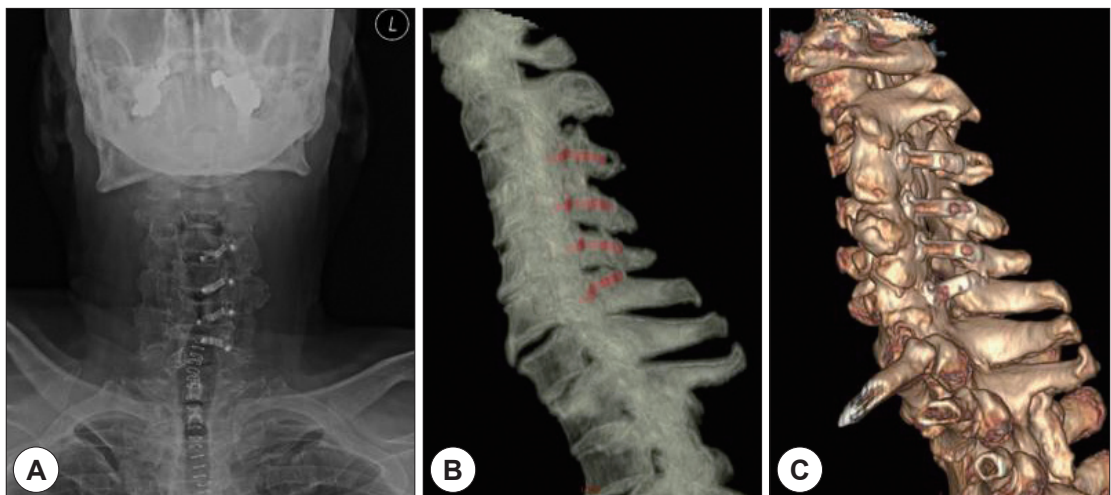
Radiologic images demonstrating cervical spine disease. A : Neck Soft tissue X-ray. B and C : Three-dimensional reconstructed images of cervical spine.
